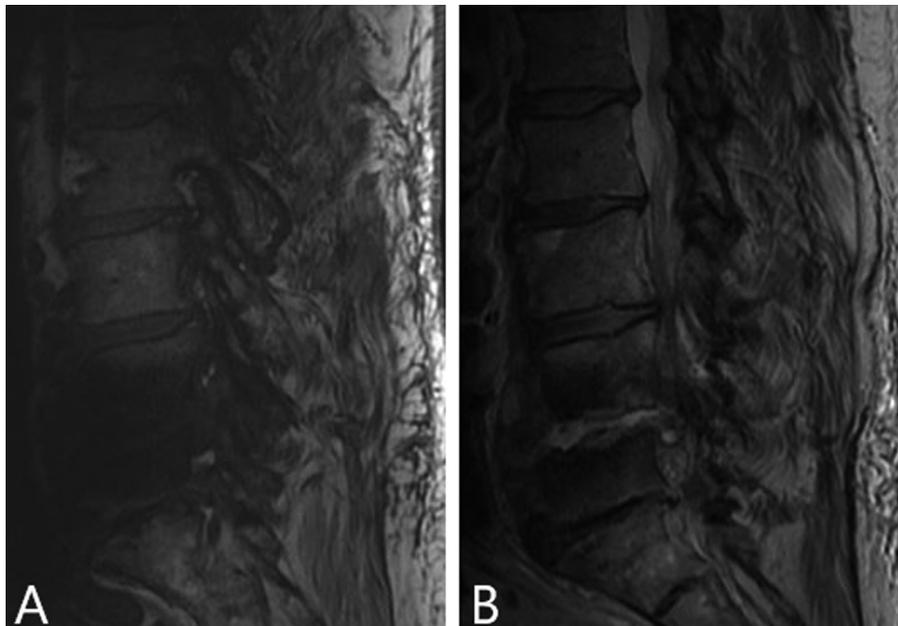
65 year old male with severe lumbar osteomyelitis and spondylodiskitis. (A) Sagittal T1 weighted MRI demonstrating L4-L5 disc space and adjacent marrow hypointensity. (B) Sagittal T2 weighted MRI demonstrating relative hyperintensity in the same region.
